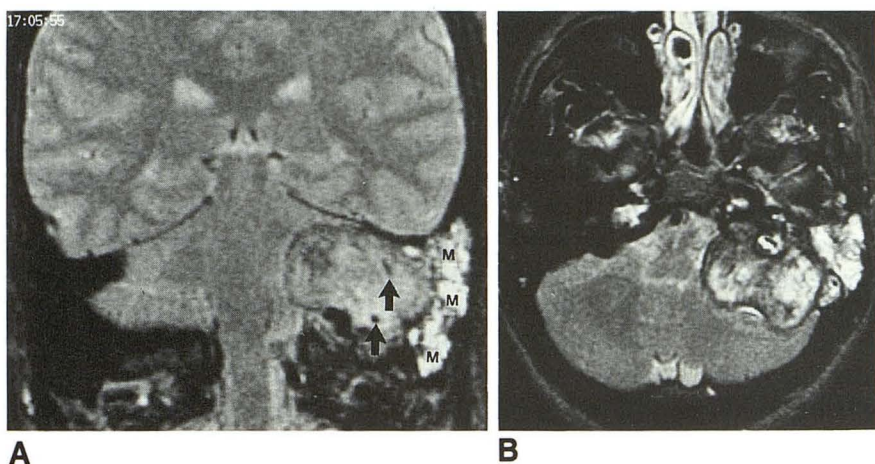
T2-weighted images.
